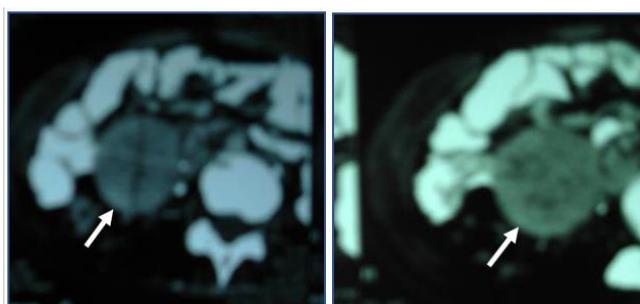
CT abdomen showing a large, solid heterogenous well defined mass of size 4x3 cm
